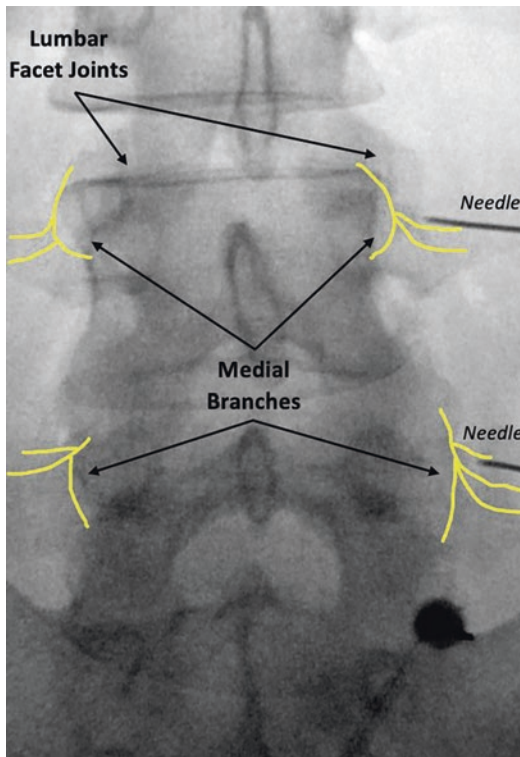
Anterior-posterior radiograph of lumbar spine to show location to lumbar medial branch nerves
